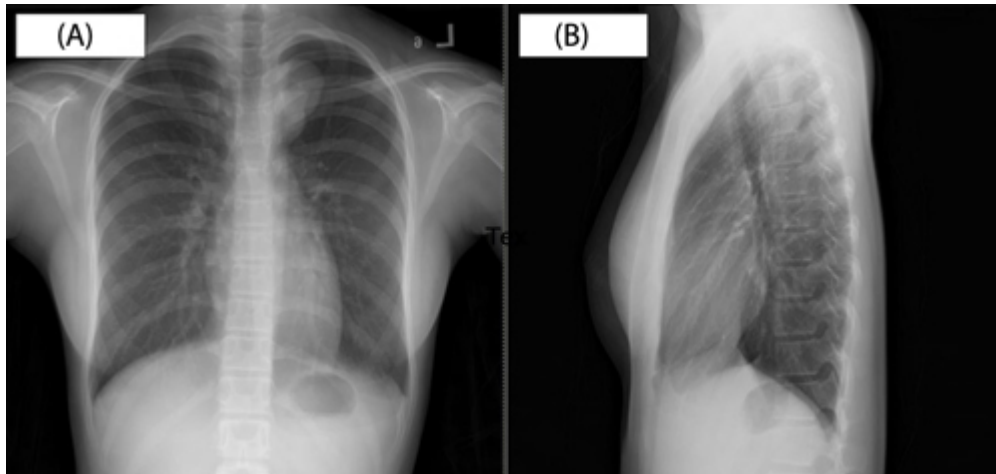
(A) A posteroanterior chest X-ray revealed a well-defined, lobulated soft tissue mass at the left paratracheal area. The mass measures 6.1×4.3 cm and causes a slight effect on the left lateral wall of the trachea. There is no rib notching, and the heart is normal in size and shape with no signs of left ventricular enlargement as might be seen in aortic coarctation. (B) A lateral chest X-ray revealed a single, superior mediastinal mass. ↩
